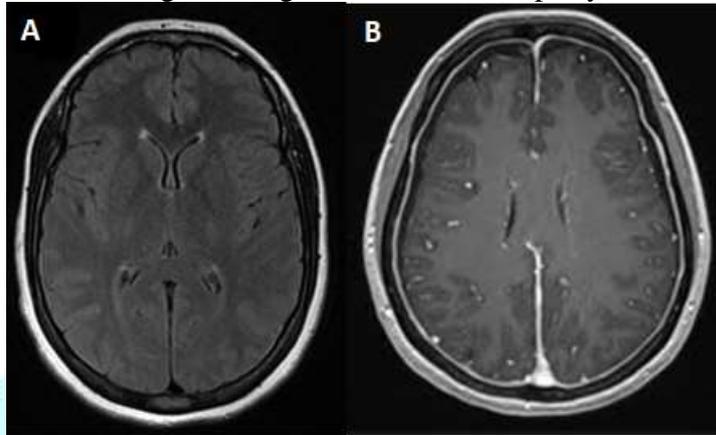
Brain MRI, axial view — FLAIR sequence (A) and contrast-enhanced T1 sequence (B) showing slit-like ventricles and diffuse pachymeningeal enhancement
